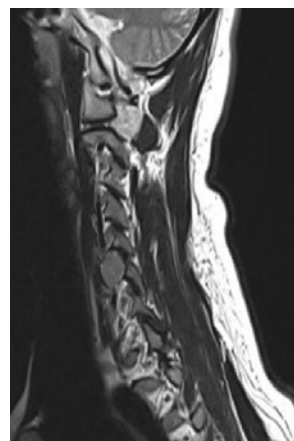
Sagittal T2W MRI sections showing an extradural tumour on left side of C5 body.
